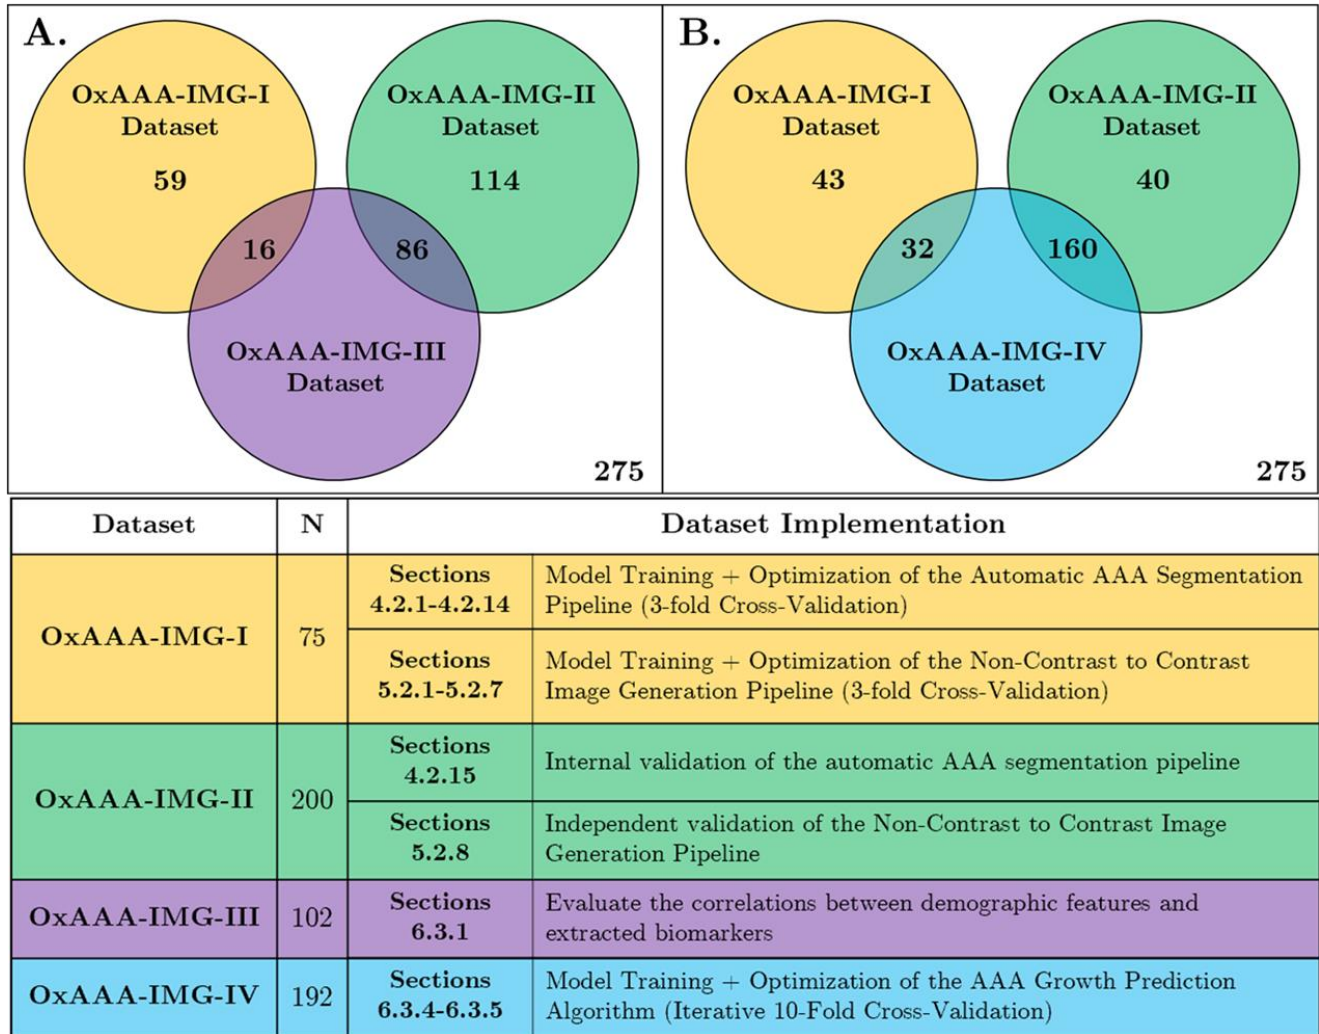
Defining the OxAAA Imaging Cohorts used in this thesis. This cohort comprised of NCCT and/or CECT images obtained from patients ($n = 275$) diagnosed with Abdominal Aortic Aneurysms (AAA). This cohort was divided into 4 datasets. The OxAAA-IMG-I dataset comprised of imaging data from 75 patients and were used for model training and optimization used in Sections 4 and 5. Subsequently, OxAAA-IMG-II dataset comprised of the remaining 200 patients and were used as an independent dataset for model validation (Chapters 4 and 5). OxAAA-IMG-III dataset was a subset of 102 patients from the larger cohort of 275 patients with prospectively collected demographic data (A.). This was used in Section 6.3.1 to evaluate the relationships between the demographic features and extracted biomarkers. Finally, OxAAA-IMG-IV dataset comprised of imaging data from 192 patients with serial CT scans (B.) that could be used to calculate AAA growth (Section 6.2.1).
